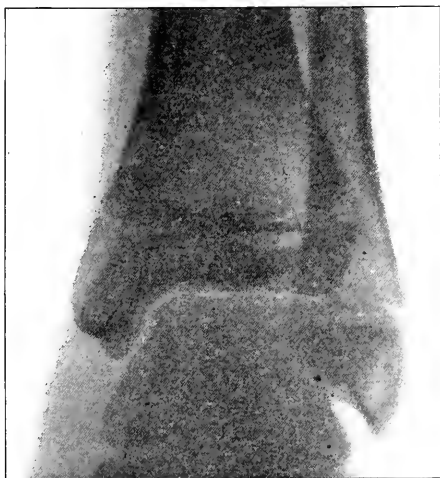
X-ray photograph of the ankle showing vertical fissure through lower epiphysis of the tibia.
